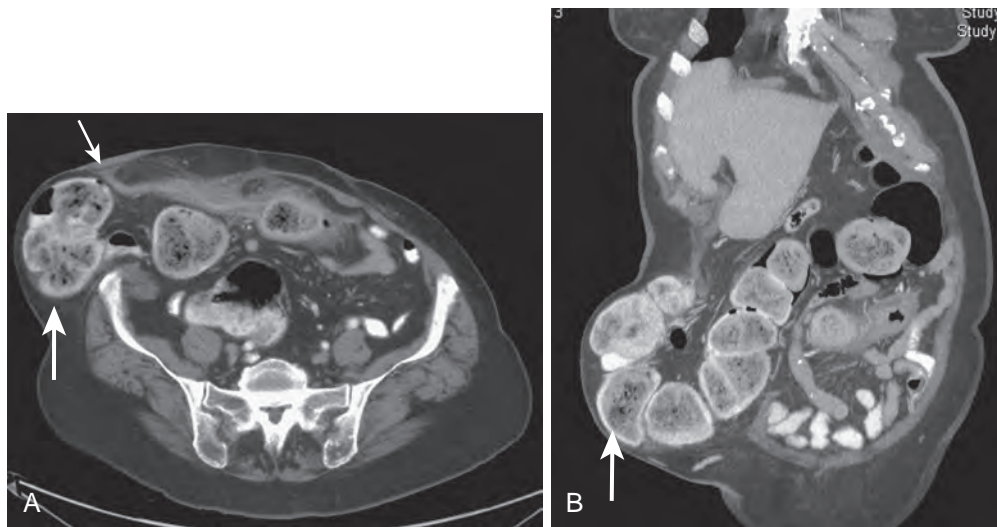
Peristomal hernia. A. Axial CT image demonstrates portions of the ascending colon (large arrow) along the posterolateral aspect of the patient's colostomy (small arrow) in a peristomal hernia. B. Coronal, reformatted CT image shows portions of the hepatic flexure of the colon (arrow) in the hernia.
